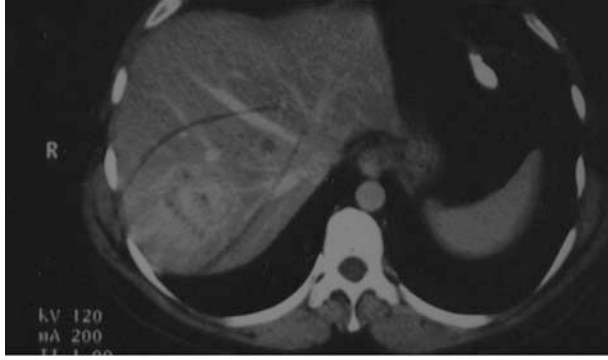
Computed tomography scan from October 8, 2002, shows multiple hyperdense masses within the hepatic parenchyma (circled).
